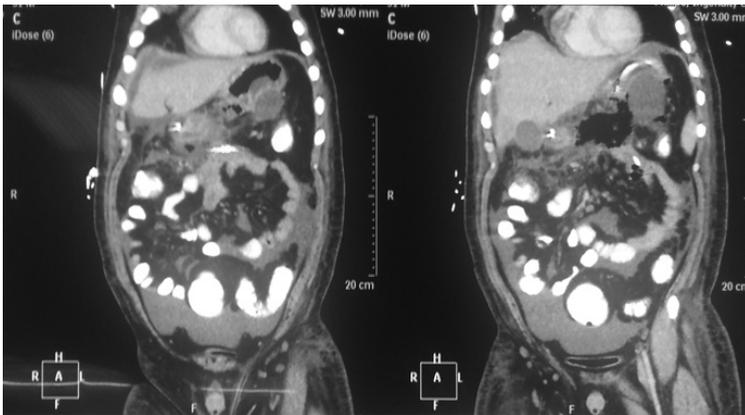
CT scan of abdomen depicting air-mottled lucency in pancreas
